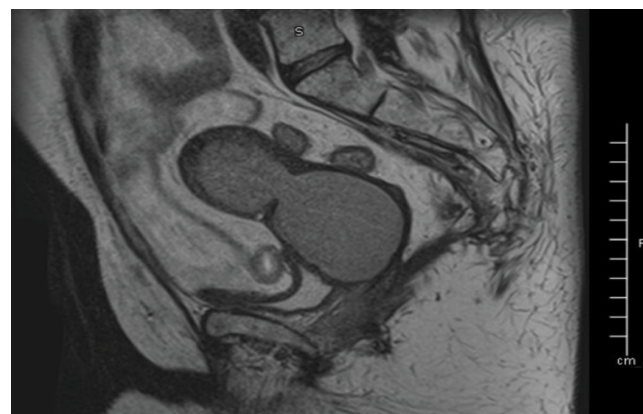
T2-weighted Pelvic MRI demonstrating fluid-distention of uterine cavity, cervix, and distal vagina.
